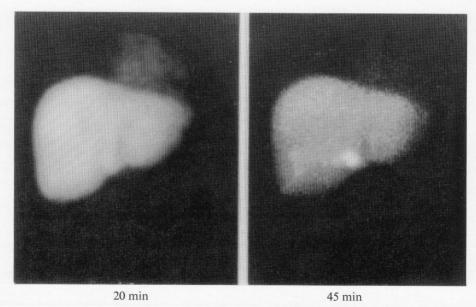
Case 2 (patient 52). Representative hepatobiliary scintigram of a patient with biliary obstruction.
